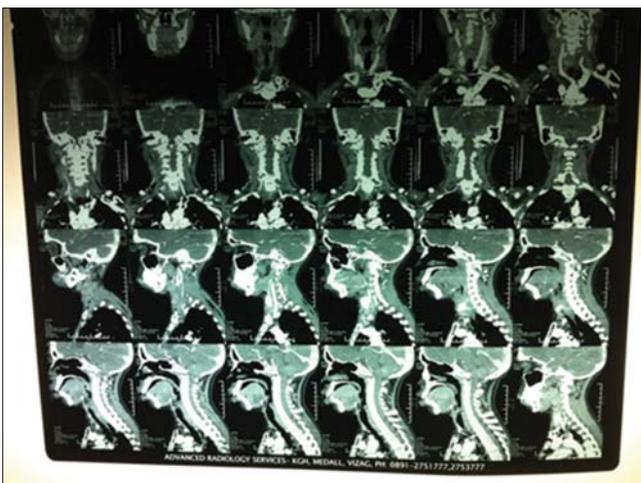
Contrast enhanced computed tomography neck showing heterogeneously enhancing hypodense lobulated mass lesion of 28 mm x 20 mm seen in right Level II/III station, right trachea esophageal groove, inseparable from hypopharynx, cricoids and proximal esophagus
